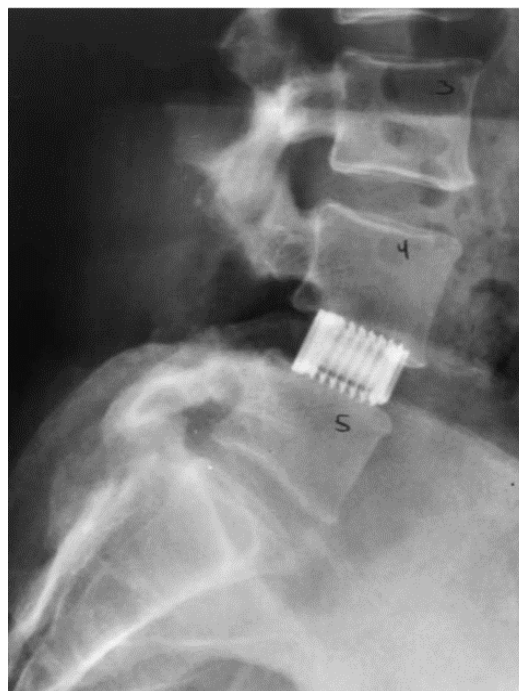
Post surgery radiograph showing the successful implantation of a titanium cage in between the vertebrae at levels L4 and L5 in a patient [199].
